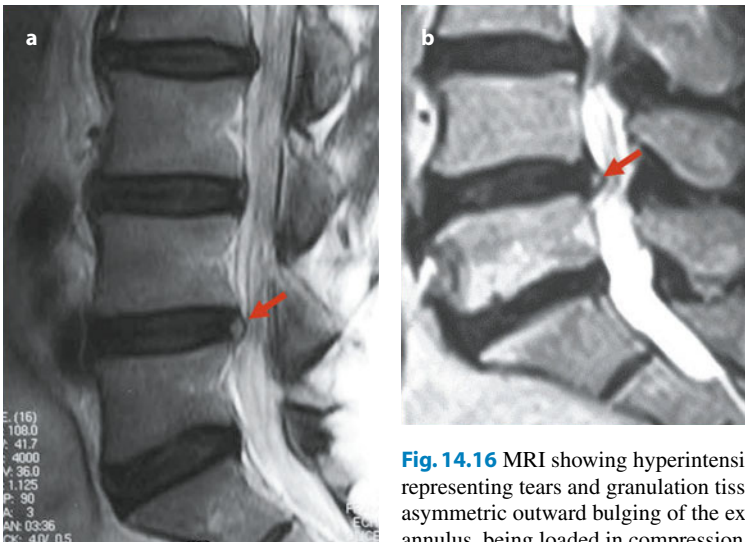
MRI showing hyperintensity zones in the posterior annulus representing tears and granulation tissue (*arrows*). In b, note the asymmetric outward bulging of the external, innervated fibers of the annulus, being loaded in compression rather than radially, owing to nuclear degeneration
